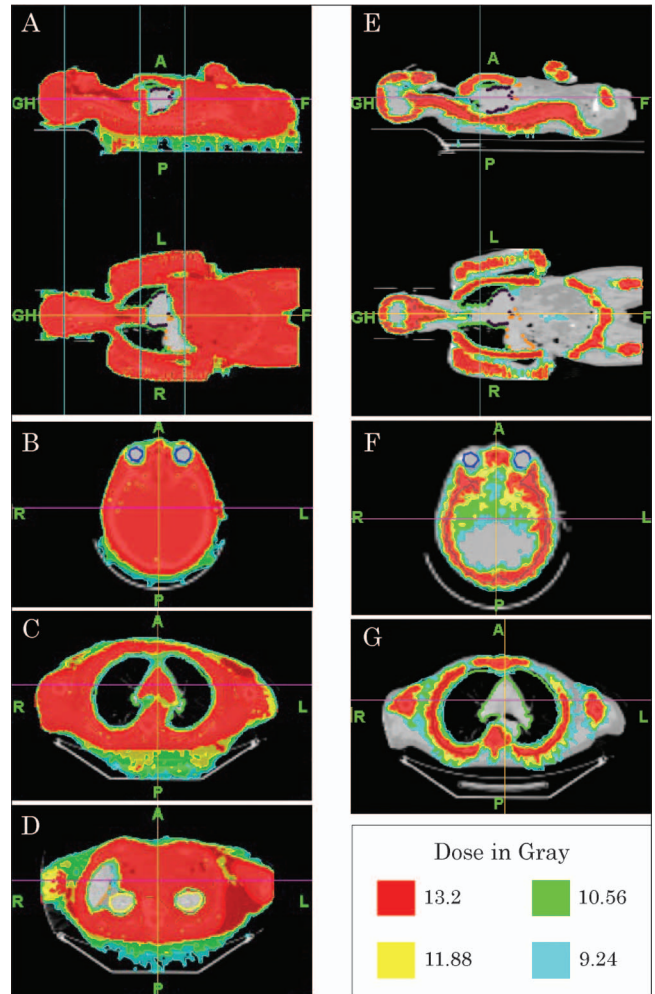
Isodose distribution shown on a patient CT, as calculated by the tomotherapy treatment planning. The left-side [(A), (B), (C), (D)] panel shows the planning dose distribution for total body irradiation. The right-side [(E), (F), (G)] shows the planning dose distribution for total bone marrow irradiation. Planning was done with a 5.0 cm field width.
